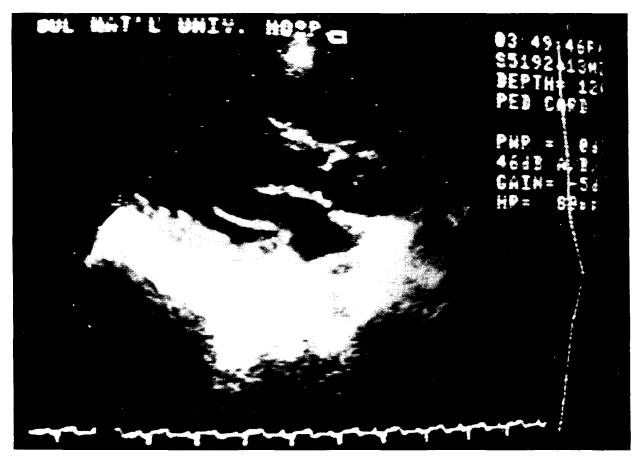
Echocardiographic findings of a patient who had PDA and subaortic stenosis. This was detected when he was 9 months old.
